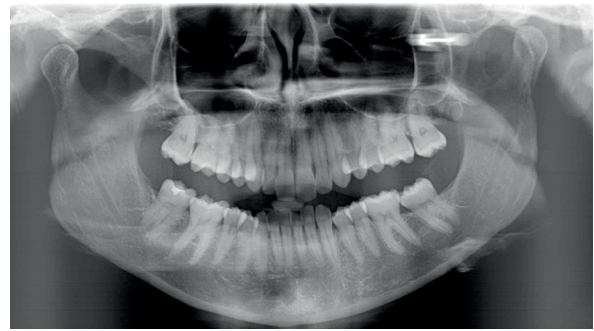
Panoramic x-ray of the same patient.
